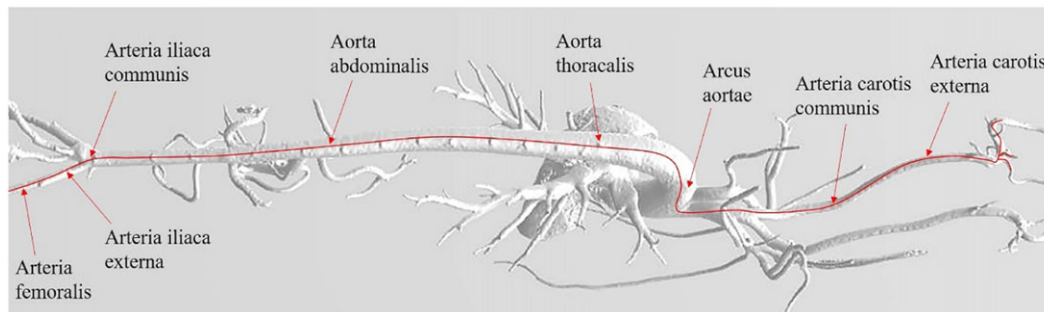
Preoperative path planning in the MRI image
